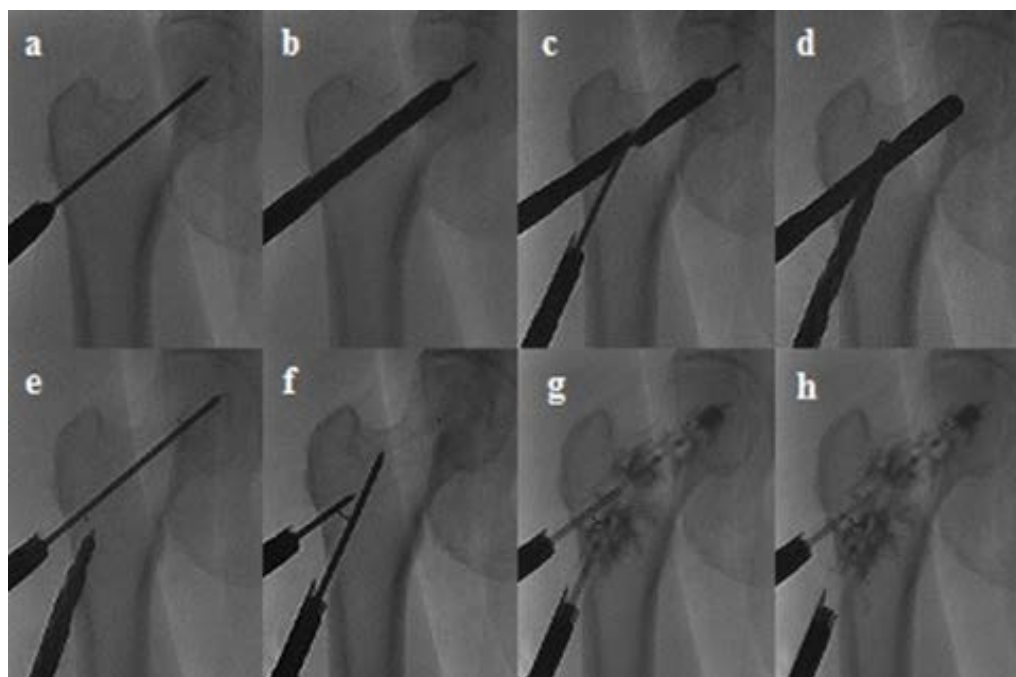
Radiographs showing the consecutive steps of the operative technique: (a) Positioning of the guide wire, (b) Drilling implant 1 location site, (c) positioning the template and the guide wire 2, (d) Drilling implant 2 location site, (e) Positioning of implant 1 (visualizing marker on the head side over the guide wire), (f) Positioning of implant 2 and control of implants positioning (the 2 distal markers form a V shape), (g, h) Cement injection on both sides.
